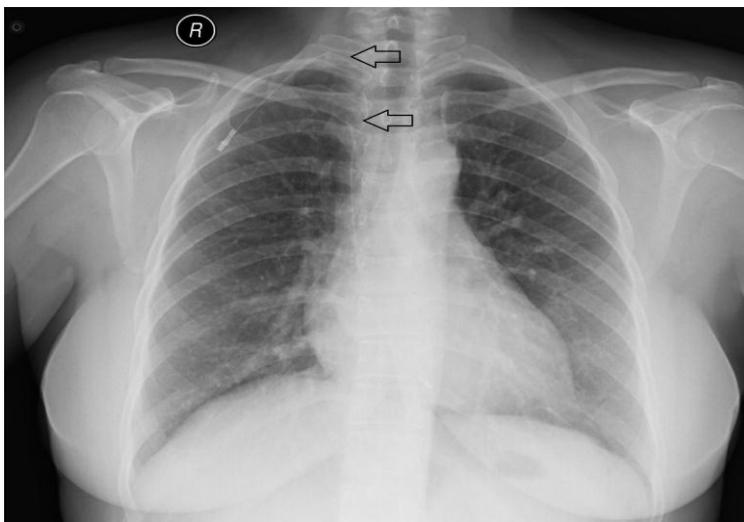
Chest PA radiograph image showing broken ends (black arrows) of central venous line.
